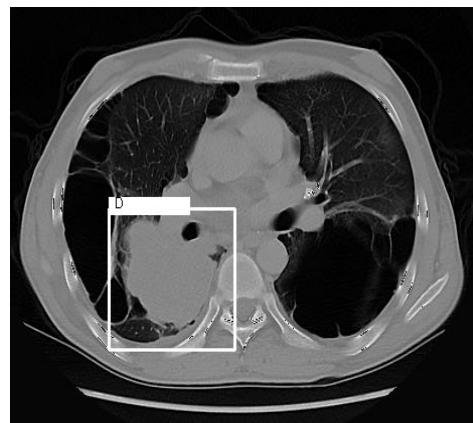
CT scan of a patient with Large
